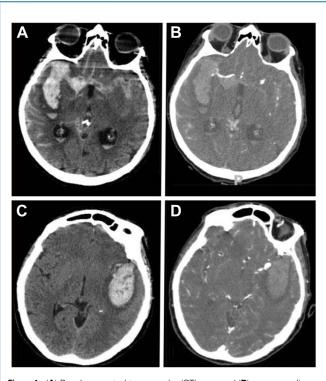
(A) Basal computed tomography (CT) scan and (B) corresponding CT angiogram showing a subarachnoid hemorrhage due to right middle cerebral artery aneurysm rupture associated with an intrasylvian hematoma. (C) Basal CT scan and (D) corresponding CT angiogram showing a subarachnoid hemorrhage due to a left middle cerebral artery aneurysm rupture associated with an intraparenchymal hematoma.
